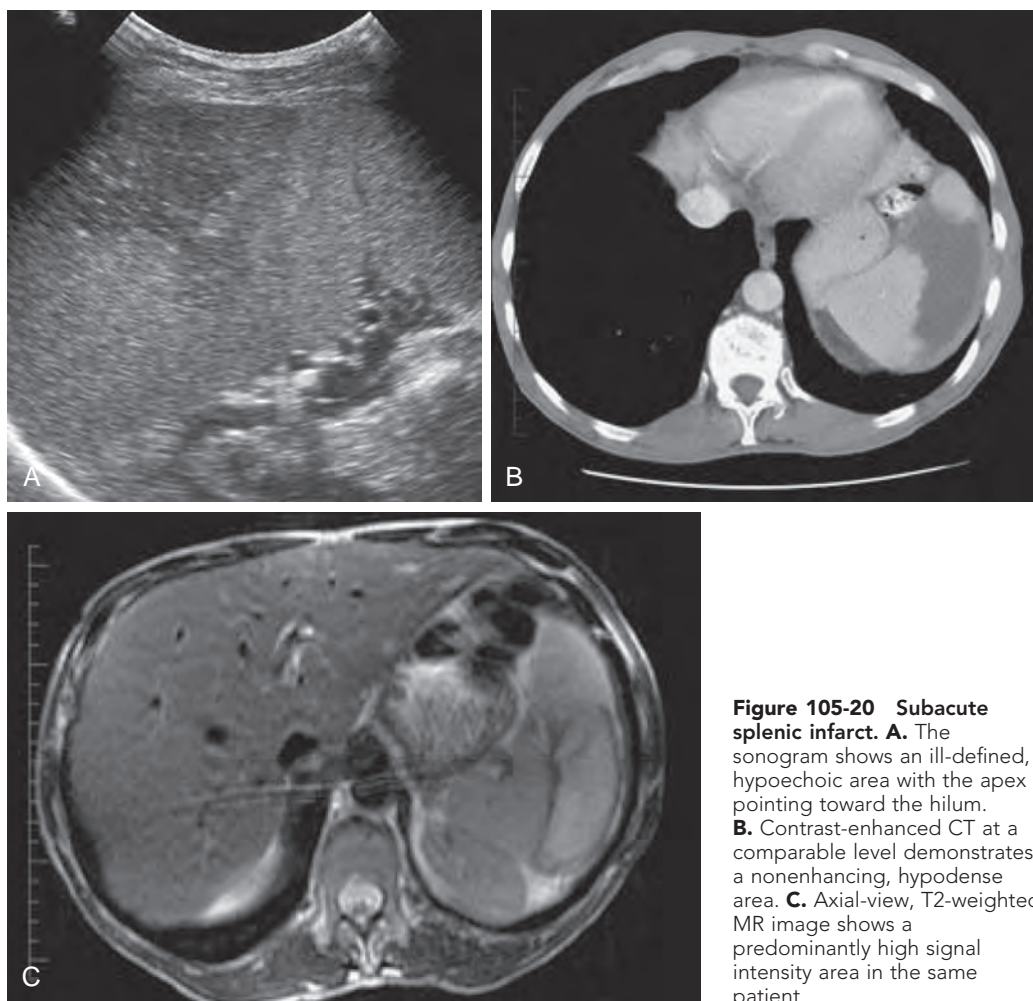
Subacute splenic infarct. A. The sonogram shows an ill-defined, hypoechoic area with the apex pointing toward the hilum. B. Contrast-enhanced CT at a comparable level demonstrates a nonenhancing, hypodense area. C. Axial-view, T2-weighted MR image shows a predominantly high signal intensity area in the same patient.
